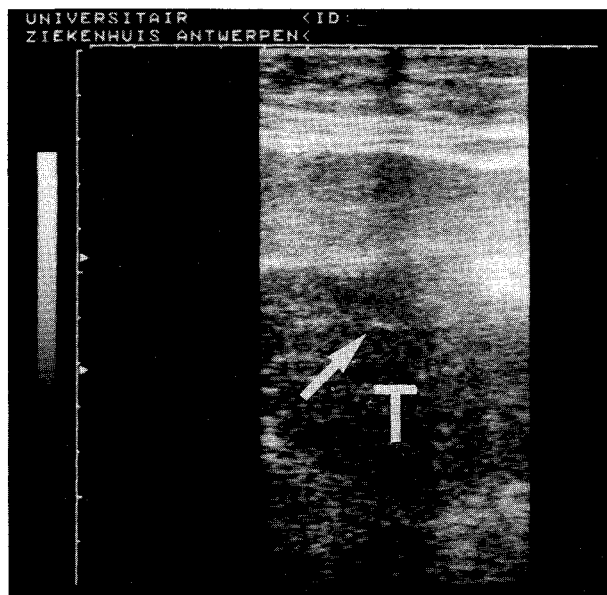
Ultrasound image with the linear array puncture transducer showing the needle tip (arrow) in a liver tumour (T).
